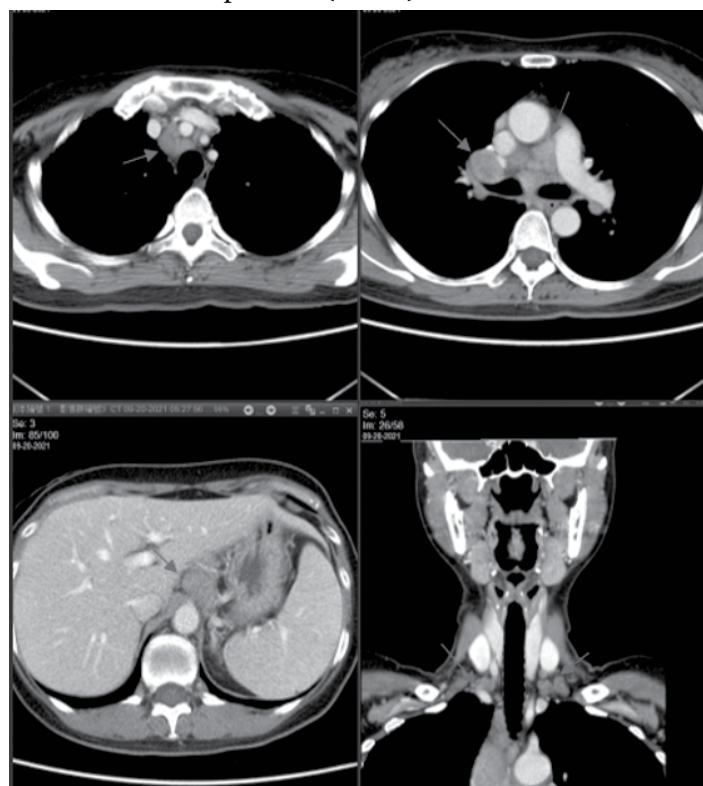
Chest CT Scan axial and coronal views showing lower paratracheal, right hilar, celiac axis and lower cervical lymphadenopathy.
